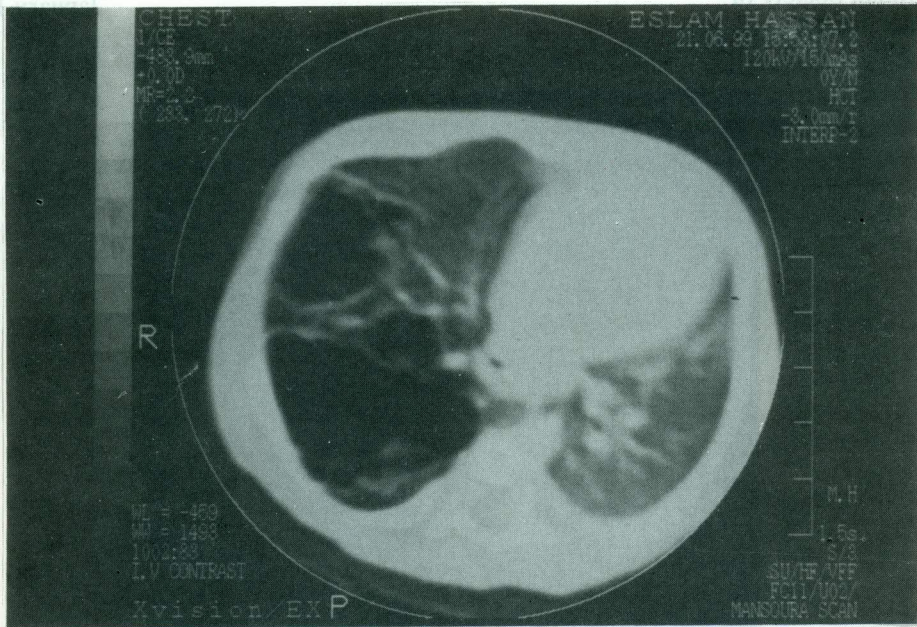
CT scan of an infant with right upper and middle lobe Congenital cystic adenomatoid malformation before operation.
